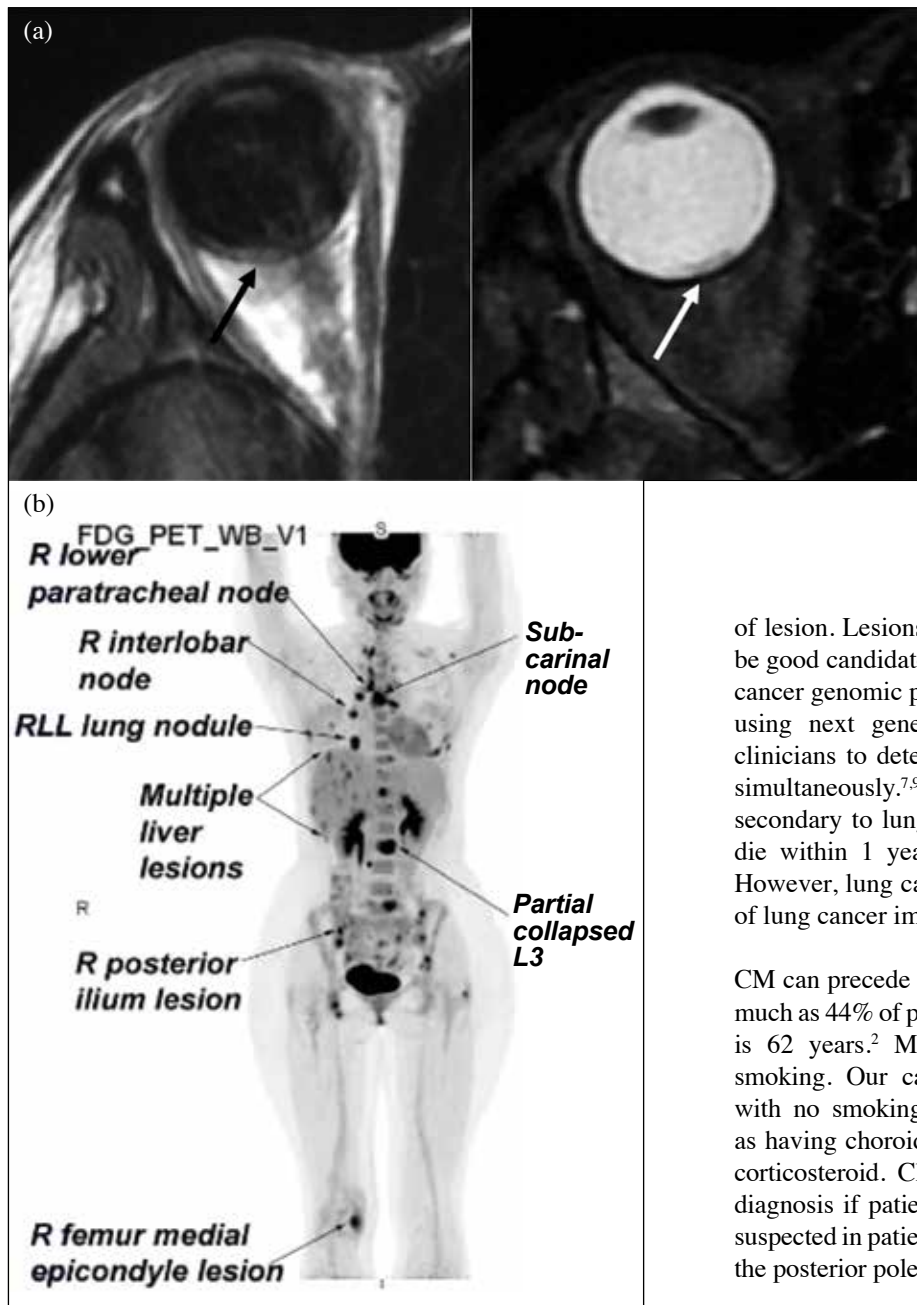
(a) Magnetic resonance imaging of the orbit on presentation showing a peripapillary choroidal mass hyperintense on T1-weighted image (black arrow) and hypointense on T2-weighted image (white arrow). (b) Positron emission tomography on presentation showing multiple hypermetabolic pulmonary nodules, mediastinal lymph nodes, and metastatic lesions in the liver, lumbar spine, and the right femur medial epicondyle.
